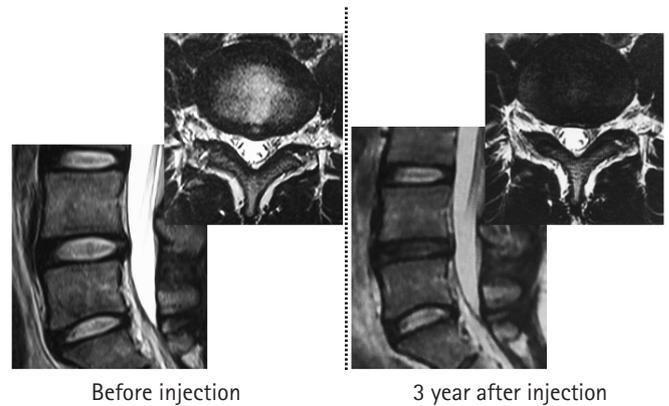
Magnetic resonance images showing a high-intensity zone before and after intradiscal injection in a female elite skier and Olympian. Intradiscal injection was effective in decreasing the pain, and she was able to attend the next Olympic Games. Three years after the injection, although her disc degeneration had advanced, the high-intensity zone was smaller.
